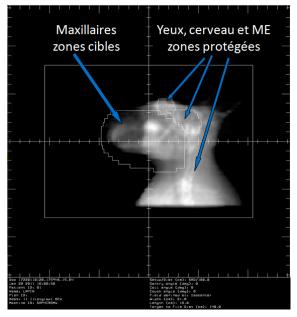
Pre-irradiation CT scan with delineation of critical organs.
